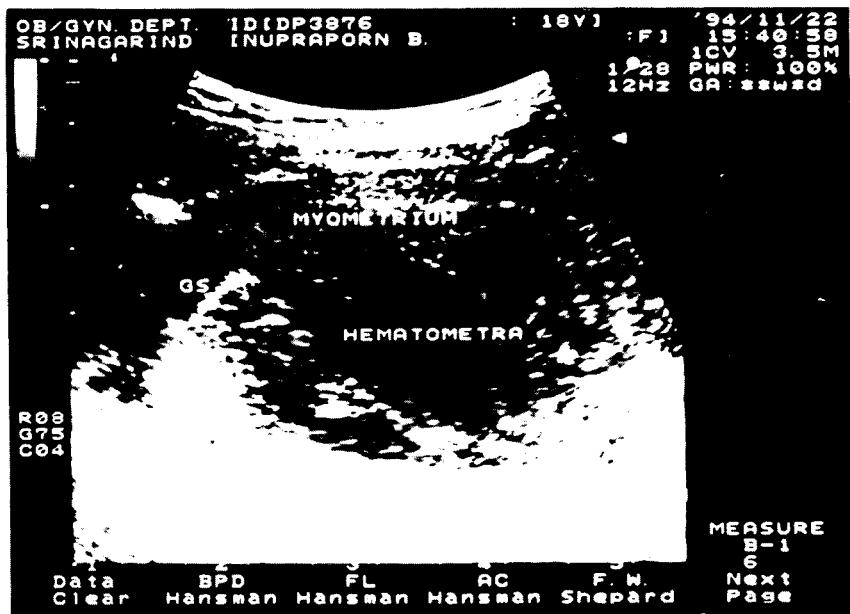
Pelvic ultrasonography revealed many blood clots in the enlarged uterine cavity and a clearly discernible right cornual gestational sac (GS).
